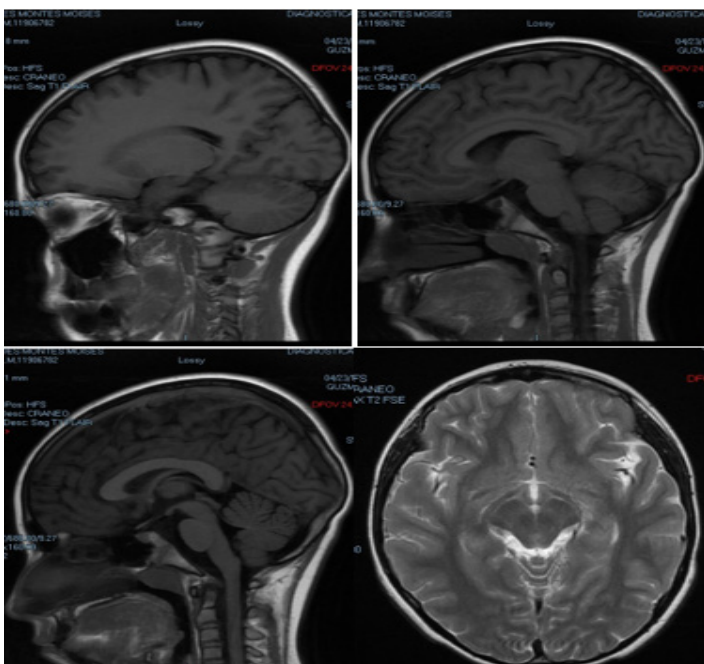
The oxygen source of the central nervous system is not the atmosphere, but the substantia nigra and the locus coeruleus, so the lines of force that are observed in some MRI studies of the brain are visible in some patients, and appear to come from these. cranial structures.
